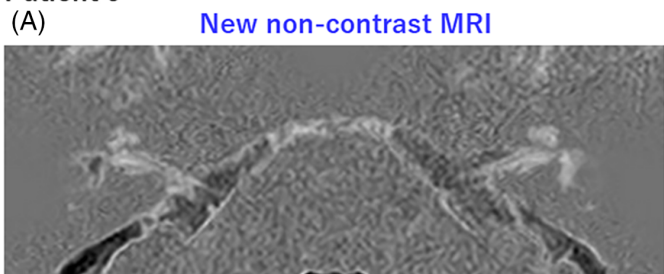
New non-contrast MRI of Patient 4. Patient 4 was a 61-year-old woman with Stage 3 right-sided Ménière's disease. (A) Positive endolymph image (PPI), positive endolymph image (PEI), and PPI - PEI. (B) Inner ear at the cerebellopontine angle. (C) Magnified images of the inner ear. On new non-contrast MRI, lesions are evident with decreased signal intensity and consistent with imaging and symptoms of possible endolymphatic hydrops of the right vestibule and cochlea.
